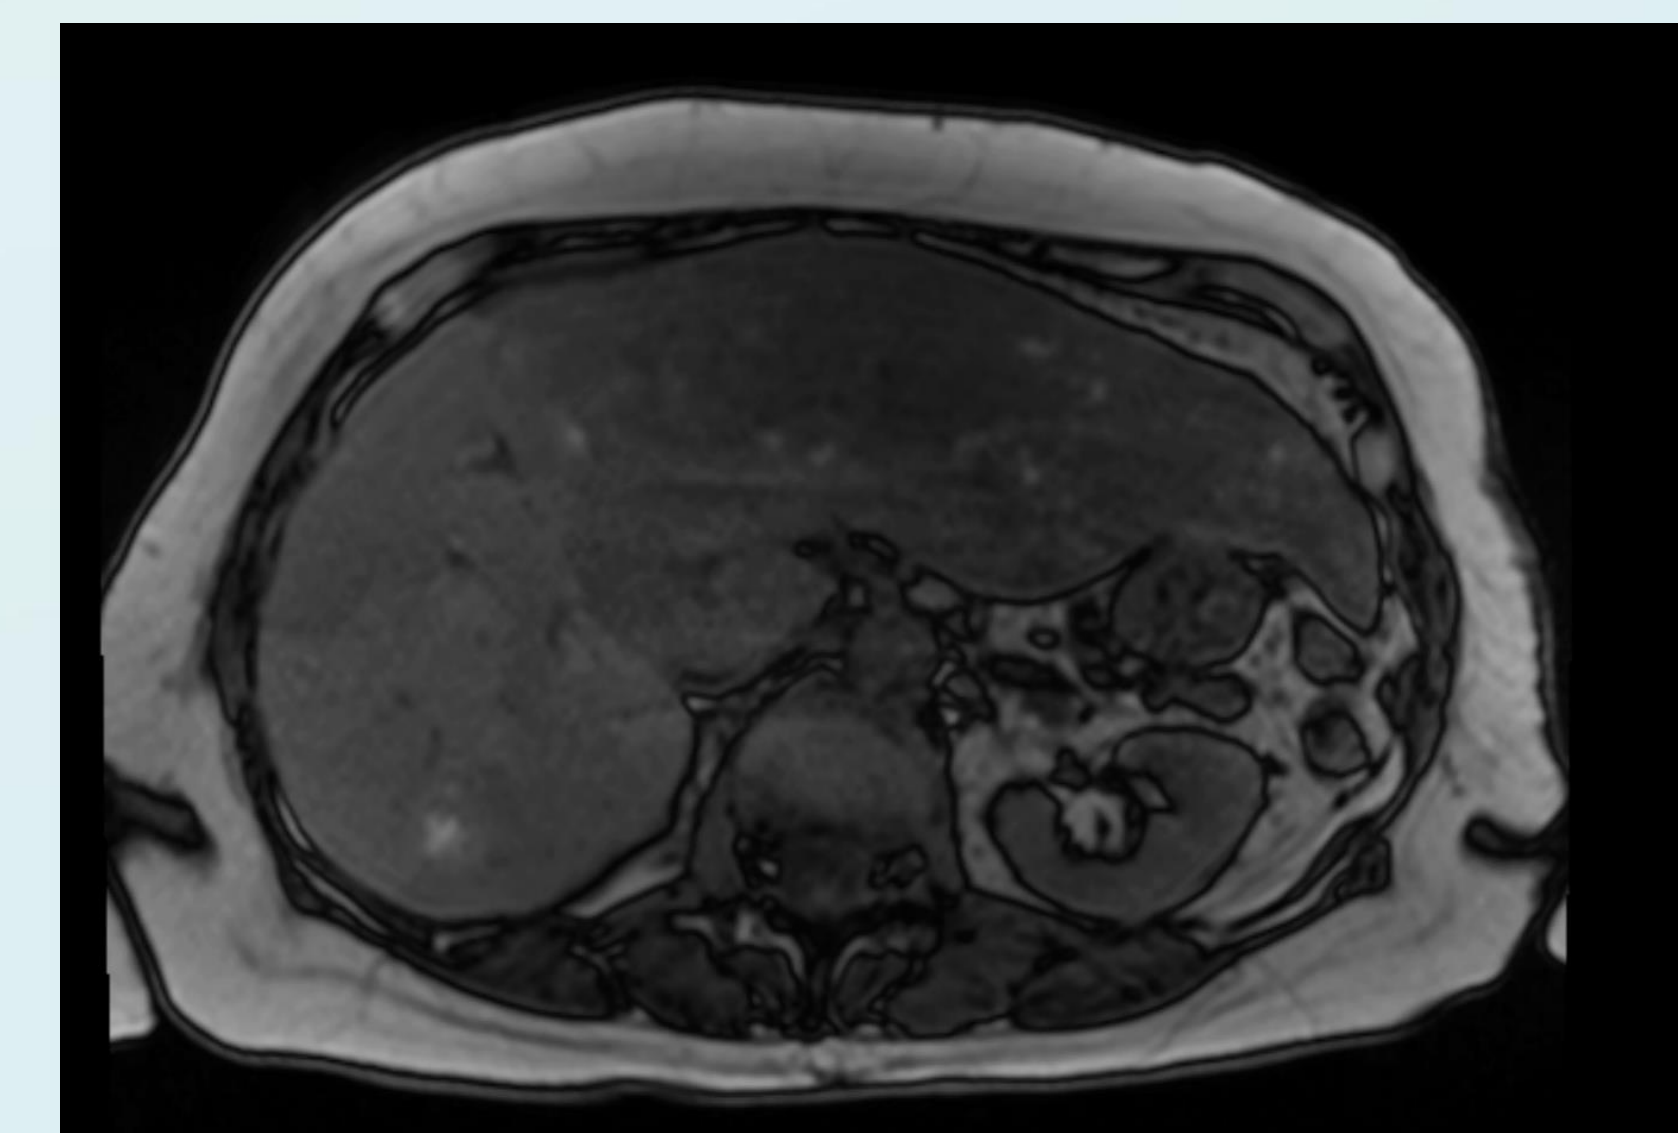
Abdominal MRI with Large Heterogeneous Mass Replacing Entire Left Hepatic Lobe
